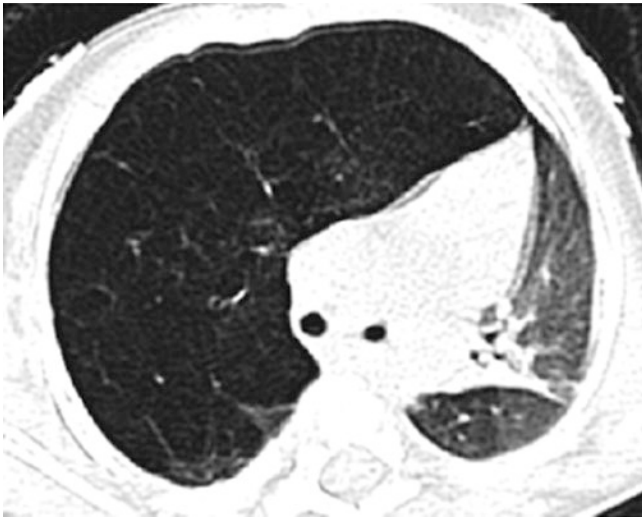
Lung window CT image in an infant with right upper lobe congenital lobar emphysema demonstrates markedly hyperinflated right upper lobe resulting in mediastinal shift to the left side. Underlying lung parenchyma of the right upper lobe despite hyperinflation was well seen on lung window CT image
